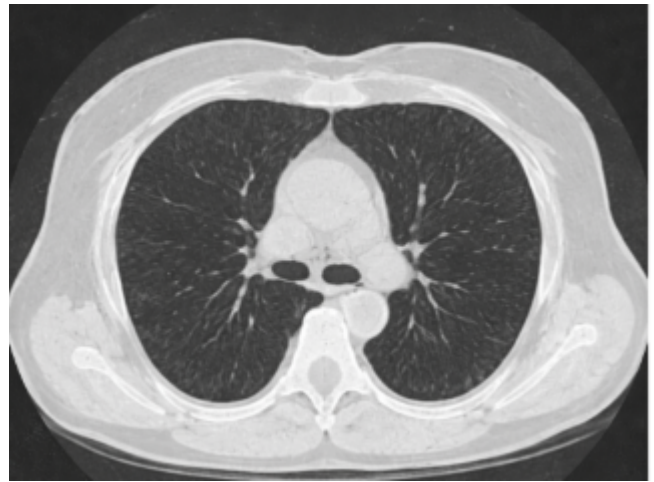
Representative CT Scan of a Non-Lung Cancer Patient
